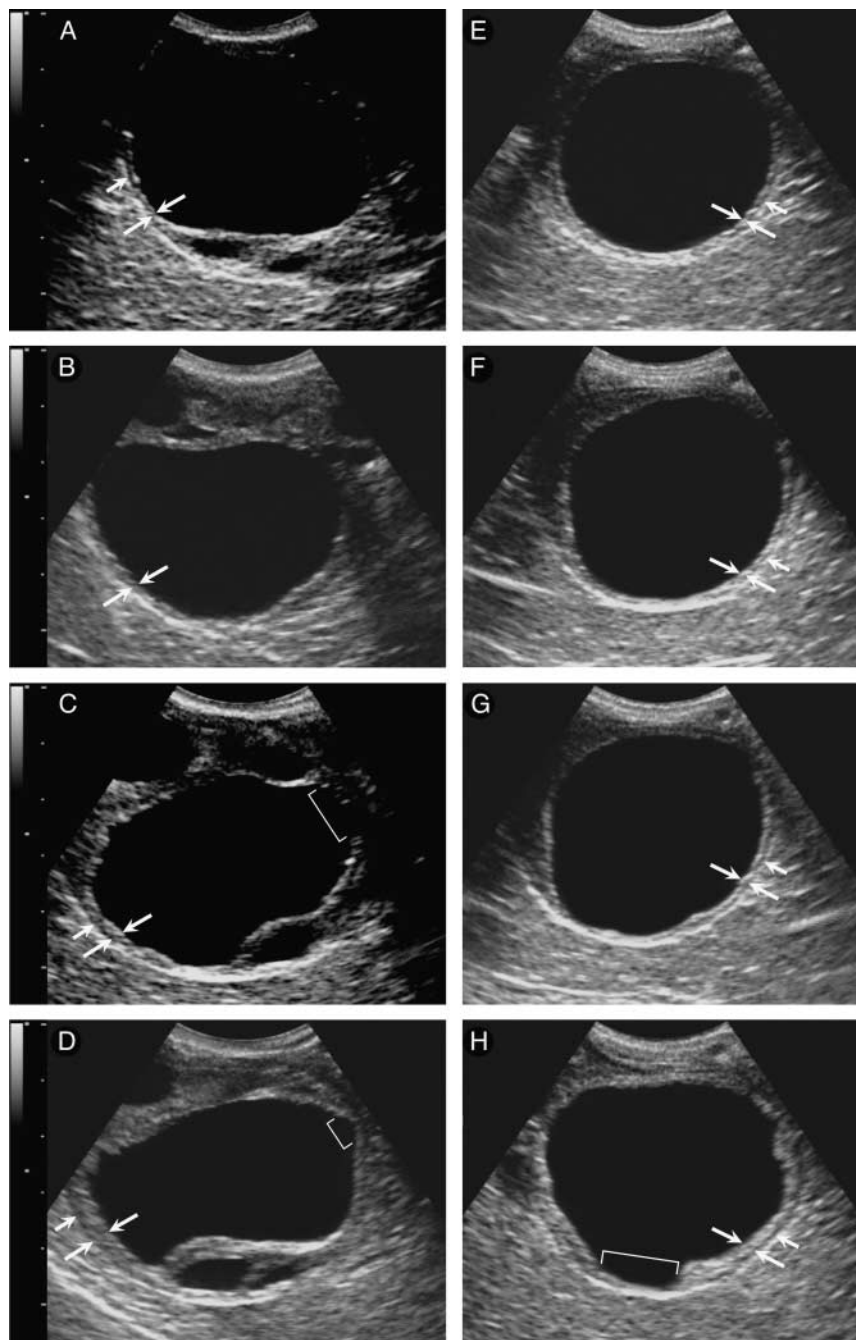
Sequential B-mode ultrasonograms of preovulatory follicles of two mares at different hours after the largest follicle reached ≥ 35 mm (hour 0, treatment time). In the sonograms in the left column, follicles of a control mare are shown at hours 0 (A), 12 (B), 36 (C) and 40 (D). Ovulation was detected at hour 41. In the right column, follicles of an hCG-treated mare are shown at hours 0 (E), 12 (F), 24 (G) and 37 (H) after treatment at hour 0. Ovulation was detected at hour 39. As ovulation approached (top to bottom) for each mare, the granulosa (large opposing arrows) became thicker. Segments of the follicular wall with an anechoic band (single short arrows) are shown for both mares. Note the decreased thickness of the granulosa at the apical area (square brackets), when compared with the thicker opposite granulosa. Distance between graduation marks (left) is 1 cm.
